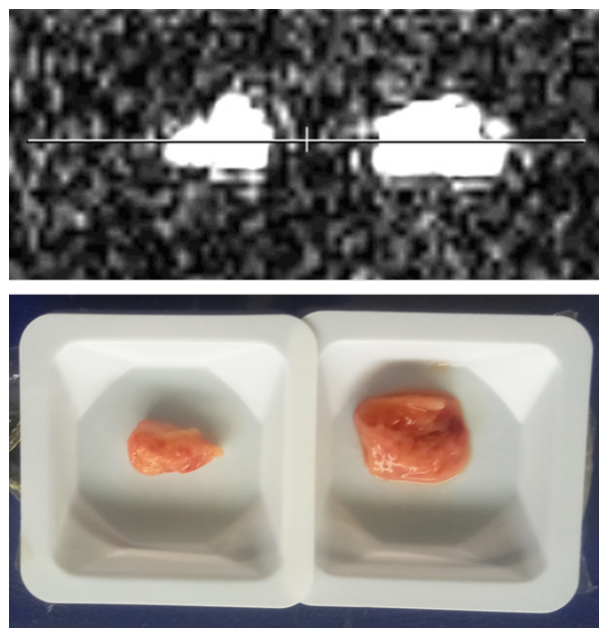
The MR image of the calibration sequence presenting the method of planning the examination and the selection of the scanning layer (layer thickness 2mm) and the same cancer tissue and health tissue of larynx on real photo
